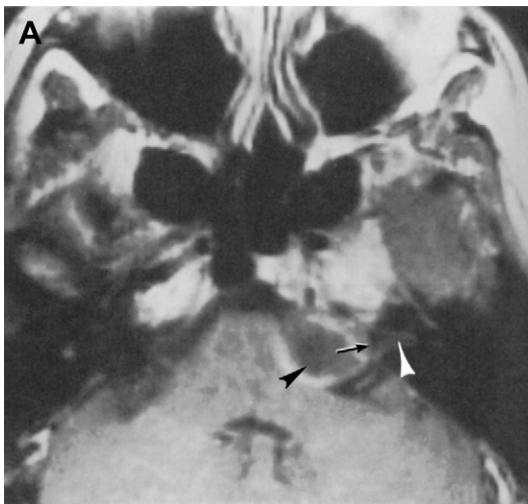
(A) T₁-weighted postgadolinium magnetic resonance image. Trigeminal neuroma. Lesion in the CPA cistern shows a low density cystic center (*black arrowhead*). The lesion extends into the porus (*arrow*) but does not involve the deep fundus (*white arrowhead*) of the internal auditory canal. (B) T₁-weighted postgadolinium image. Slightly higher slice shows the lesion in the CPA cistern protruding into Meckel's cave (*arrow*) indicating the identity of the tumor.
